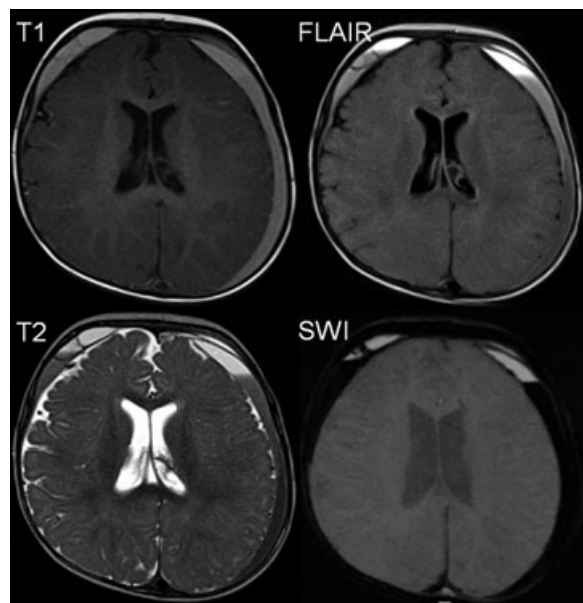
Different MRI sequences (T1, FLAIR, T2, SWI) can help to better characterize, grade, and possibly date subdural effusions/hematomas. This valuable information may assist diagnosis of nonaccidental TBI.
